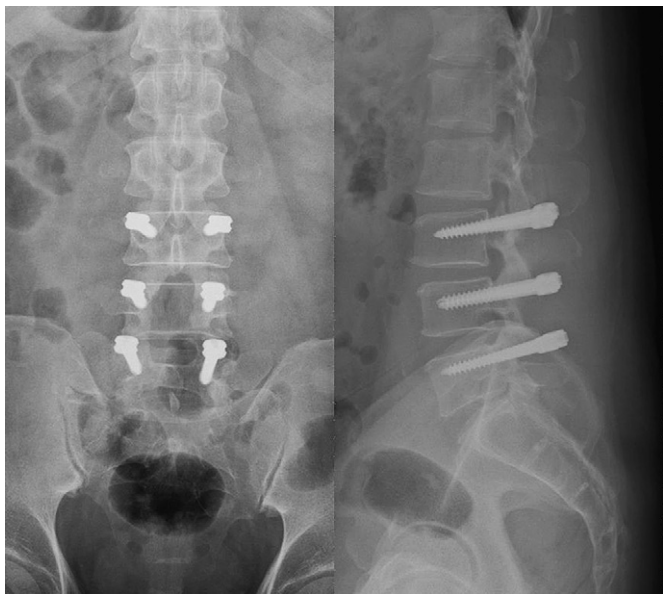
A 50-year-old man diagnosed with L3–5 degenerative disc disease and associated stenosis underwent L3–5 posterior decompression with Dynesys instrumentation. Postoperative radiography showed good alignment and positioning of pedicle screws.
